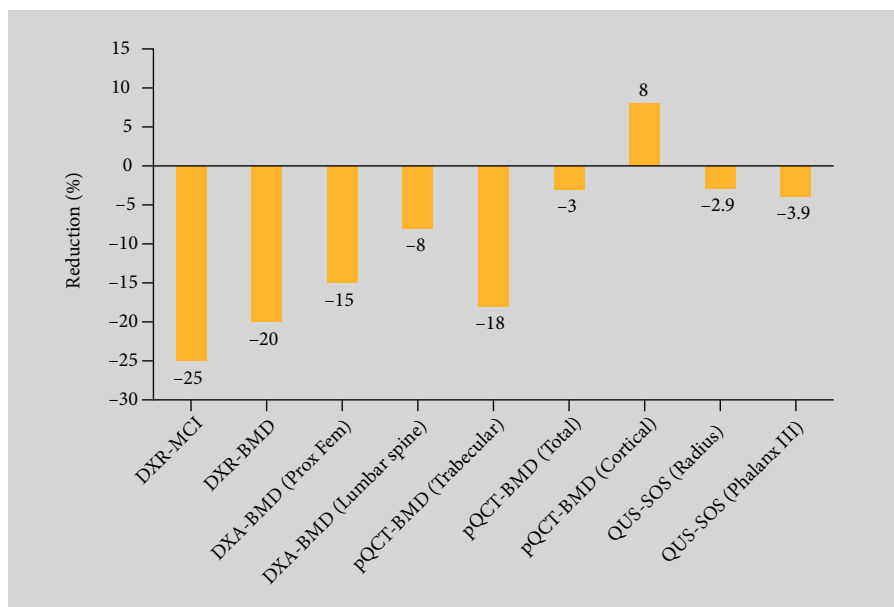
Severity-dependent bone loss of different evaluated osteodensitometric methods between a Larsen score of 1 and 5. BMD, bone mineral density; DXR, digital X-ray radiogrammetry; DXA, dual energy X-ray absorptiometry; MCI, metacarpal index; pQCT, peripheral quantitative computed tomography; QUS, quantitative ultrasound; SOS, speed of sound. Reproduced with permission from Pfeil et al [20] ©Wiley.
